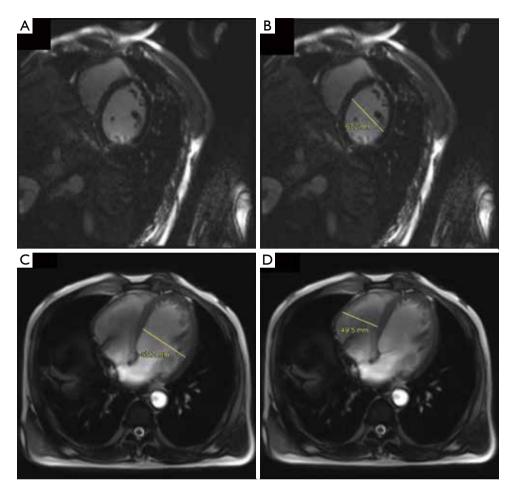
Heart MR3T showed enlargement of the whole heart. (A,B) On the short axis, the left ventricle's diameter was 63.2 mm at the end of diastole; (C,D) the diameter of left and right ventricle was 65.2 and 49.5 mm, respectively (through the axial view). MR3T, magnetic resonance imaging at 3 T (GE Signa Excite HD scanner) enhancement scanning.
